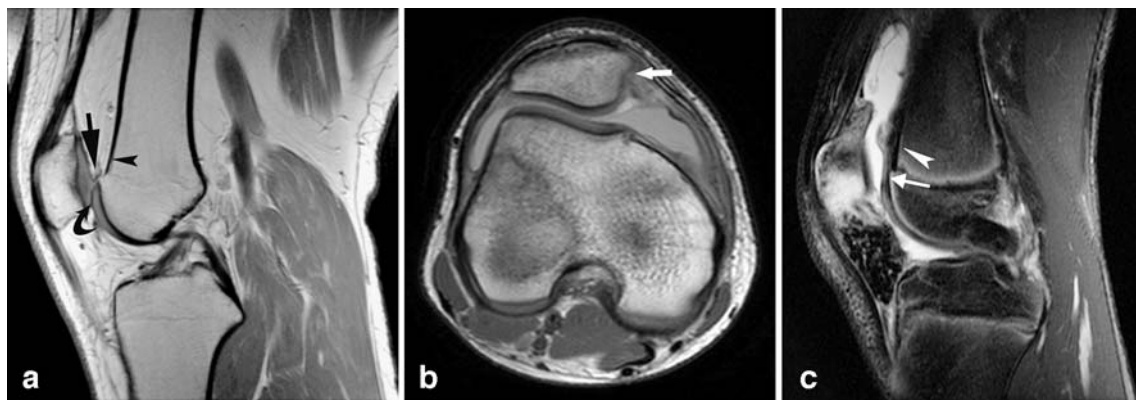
MR images in a 16-year-old girl. a Sagittal PD image. There is a step-like transition from the anterior femoral cortex (*arrowhead*) to the trochlear articulating surface (*curved arrow*). Note the normal smooth transition seen in Fig. 2. The nipple-like excrescence at the anterosuperior margin of the trochlea (*arrow*) is well seen and is firm evidence of patellar trochlear dysplasia in this girl with a prior subluxation. b Axial PD image 3 cm above the joint line. The trochlea
